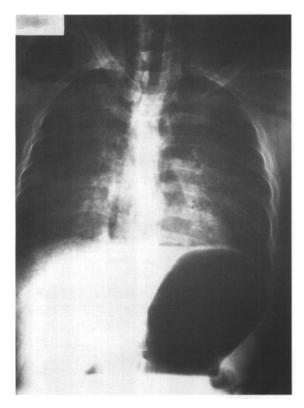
Post-mortem decompression artefact – chest X-ray. A large amount of gas is seen within the heart chambers and the left pulmonary artery, as well as in the major vessels of the neck and the subclavian vessels bilaterally. Subcutaneous emphysema is seen in the chest wall. The gaseous distension of the gastric fundus is well demonstrated. These characteristics are commonly found in divers and caisson workers who die while under pressure and who are then brought to the surface.
